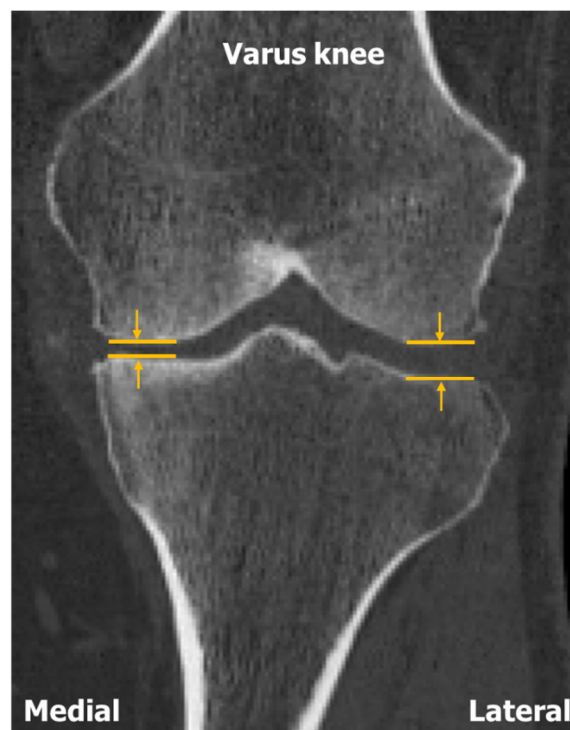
Coronal reconstruction of CT image of OA knee with varus (bow-legged) malalignment. In a varus knee, the joint space is more in the lateral side.
